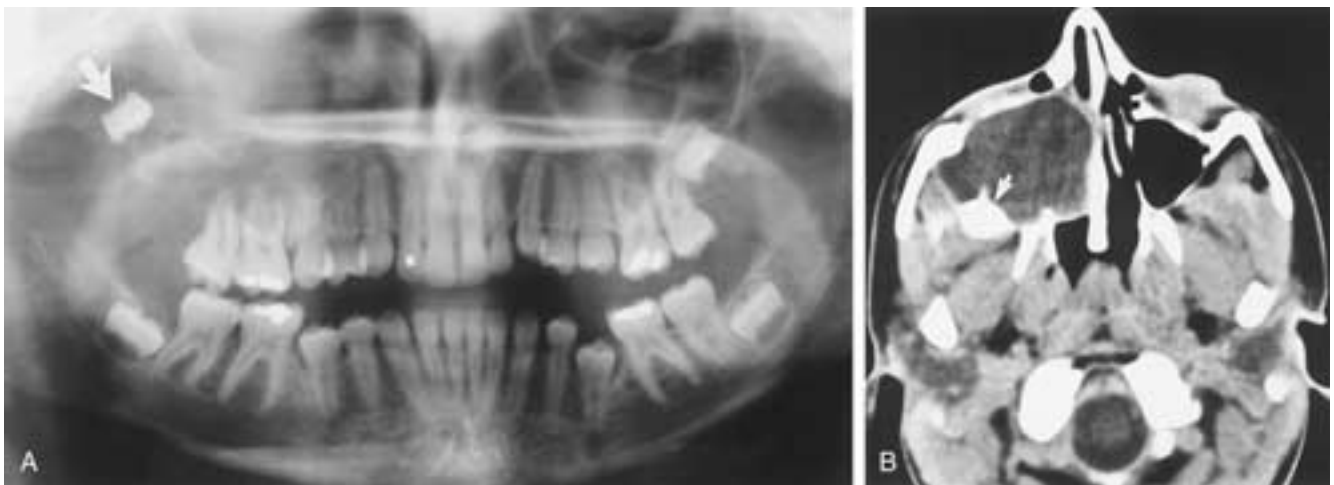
Dentigerous cyst. A, Pantomogram of the mandible and maxilla shows a displaced tooth in the upper lateral aspect of the right maxilla (*arrow*). There is a poorly defined expansile lesion in the same region. B, Axial CT demonstrates an expansile cystic lesion within the right antral cavity, with extension into the right nasal cavity and infratemporal fossa. Note the localized density at the posterior margin of this cyst representing a tooth that is incorporated into the cyst (*arrow*).
